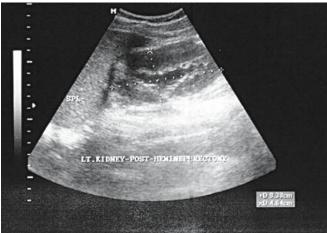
Postoperative ultrasound scan on day 5; no perirenal collection
